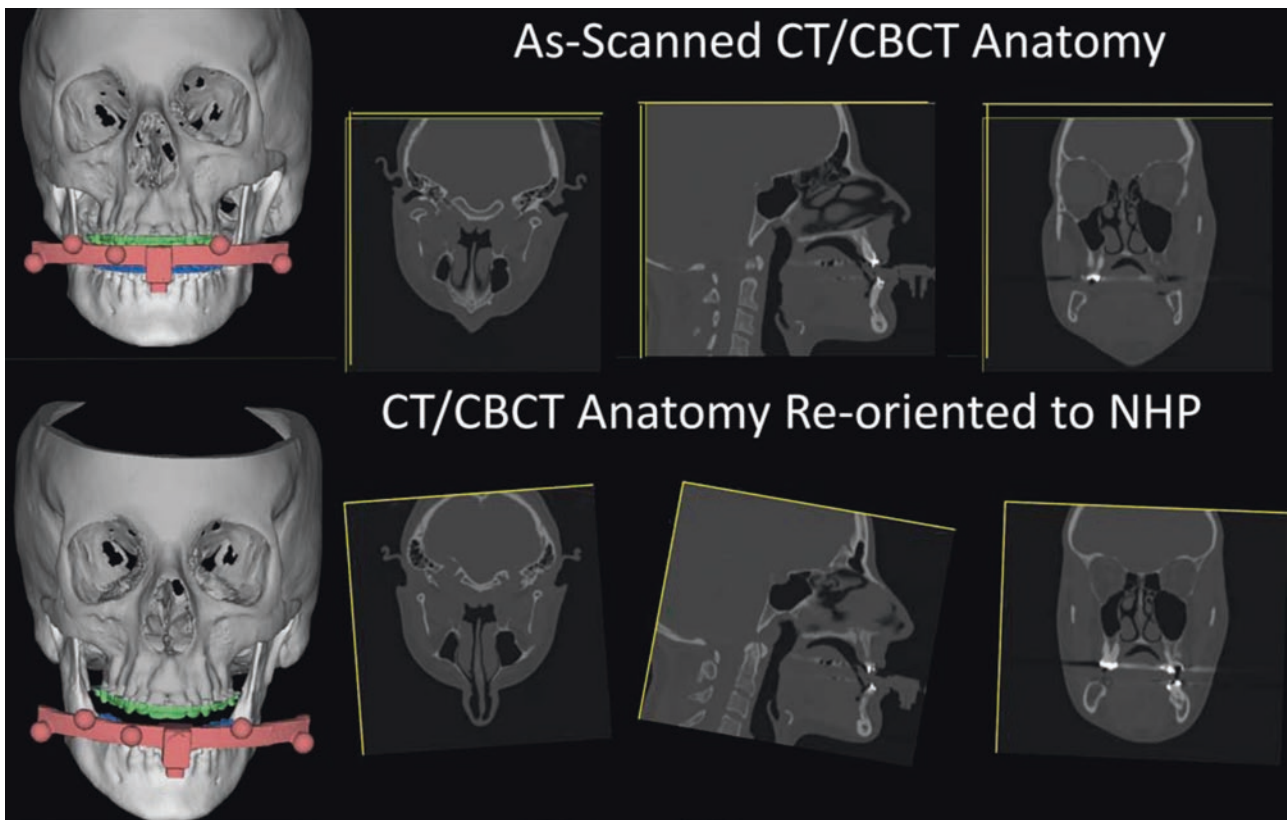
The patient is CT/CBCT scanned in centric relation wearing a facebow device and neutral head posture (NHP) is clinically recorded by the surgeon using a gyroscope device. These orientation measurements are applied to the CT/CBCT scan to reorient the patient's digital data into the proper NHP
